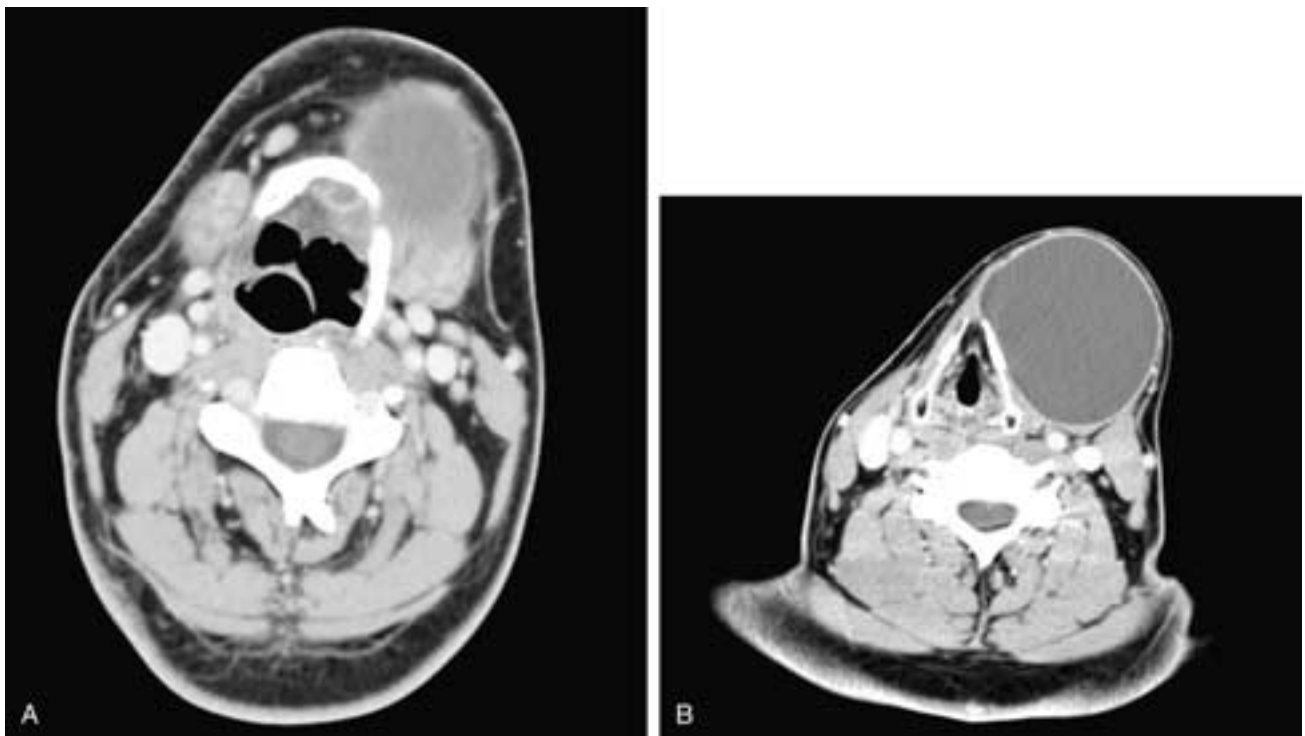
Axial CT scans at the cranial level (A) and a more caudal level (B). In B, there is a large cyst adjacent to the outer contour of the thyroid cartilage. However, the cyst is so large that the strap muscles cannot clearly be identified as draped over the cyst. In A, the upper aspect of the cyst touches the hyoid bone and a small lobulation extends dorsal to the body of the hyoid bone. This was a thyroglossal duct cyst.
